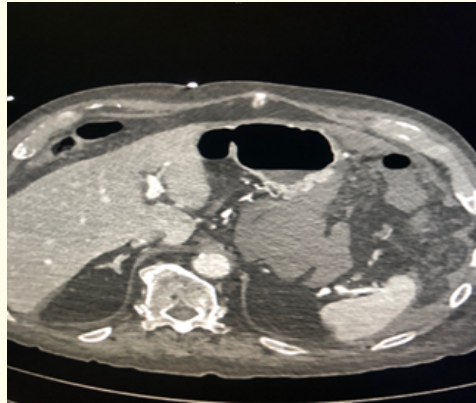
CT transverse axis, arterial phase. Posterior perigastric hemorrhagic spread.
